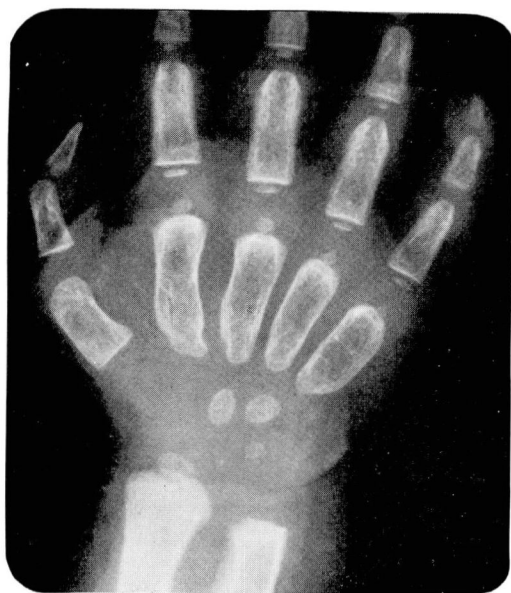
Roentgenogram of the right hand. There are widening of the medullary cavity and deformity of the metacarpus and the proximal phalanges.
